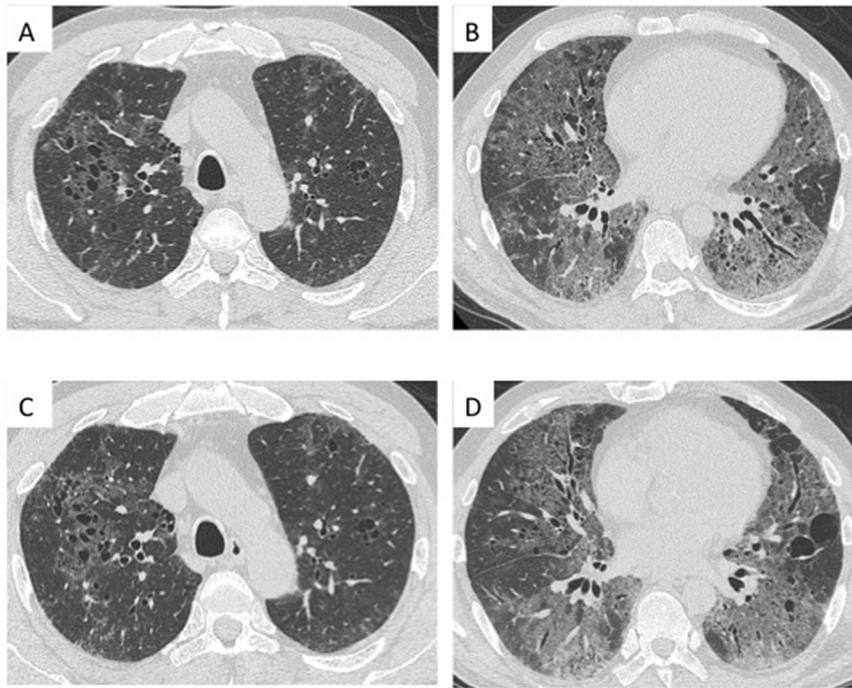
HRCT scans of the chest. (A, B) At initial presentation: Emphysema and mild GGO in the upper lobes, and uniform GGO with lower zone predominance. (C, D) After smoking cessation: Little change is evident in the upper lobes, while bilateral shadows in the lower lobes show mild improvement.
